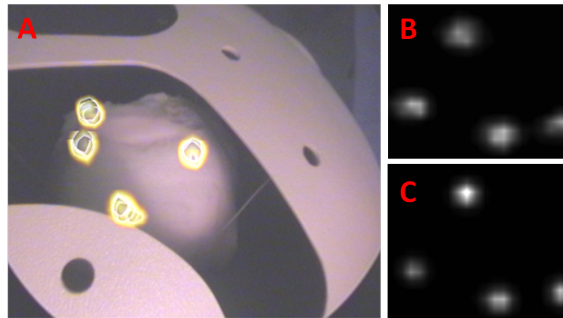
(A) First reconstructed 4 hot spots using freehand SPECT overlaid on the video image of a tracked laparoscope. (B) reconstructed slice using freehand SPECT concept vs. (C) corresponding PET slice [362]. The spots were double marked with ^{99m}Tc and ^{18}F allowing to validate the low energy spots reconstructed with freehand SPECT with PET.
